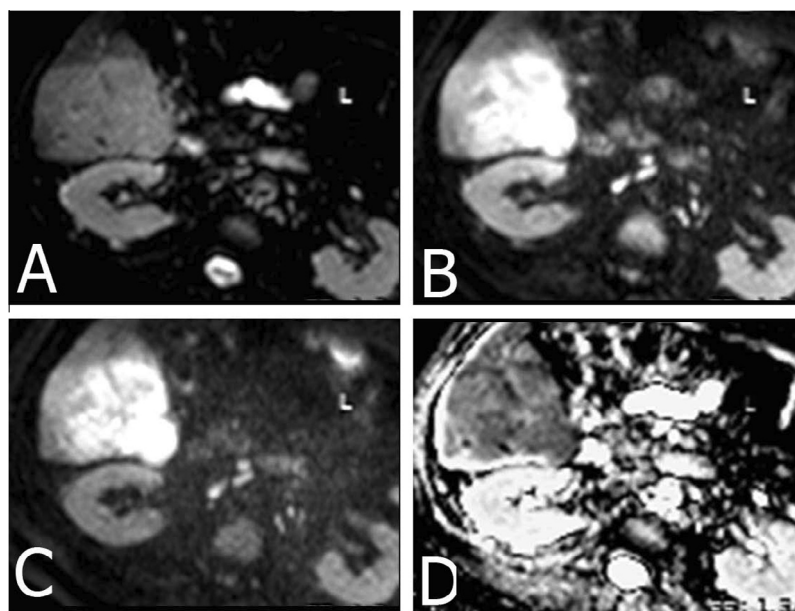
Diffusion weighted MR images of 57 year old male patient with HCC, DWI at b_0 (A), DWI at b_500 (B), DWI at b_{1000} (C). The lesion shows low SI on ADC map (D) with restricted diffusion and mean ADC value at $b_{1000} = 0.8 \times 10^{-3} \text{ mm}^2/\text{s}$.
